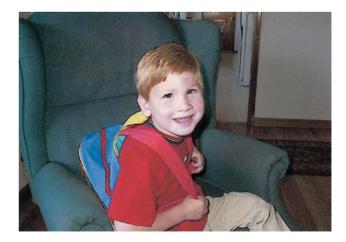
JA: A four-year-old boy with Cbl C disease. He looked quite good. His magnetic resonance images are shown in Figures 4.3 and 4.4. (Images were kindly provided by Dr GM Enns of Stanford University).
